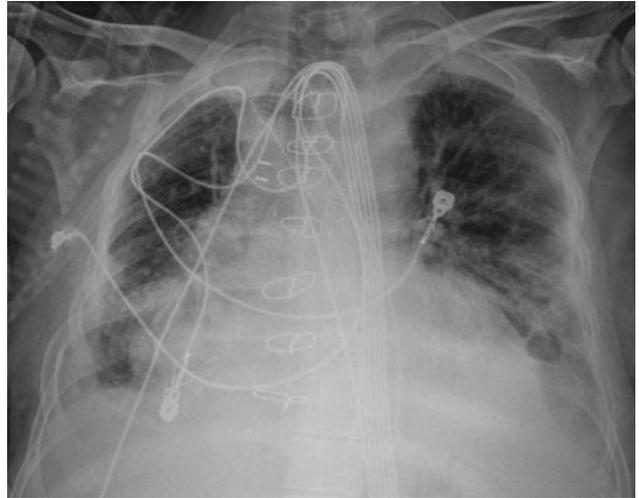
Chest radiograph demonstrating cardiomegaly with bibasilar air space disease and small pleural effusions, with stable sternotomy wires, esophageal stent, and vascular stent present with stable widened mediastinum due to a mediastinal hematoma.
